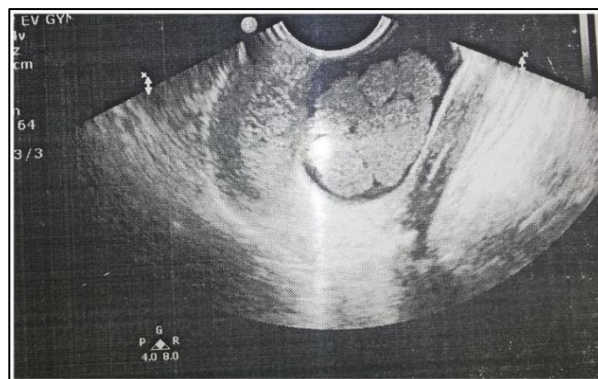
The ultrasonic scan of the area showing a lesion with distinct boundaries.
